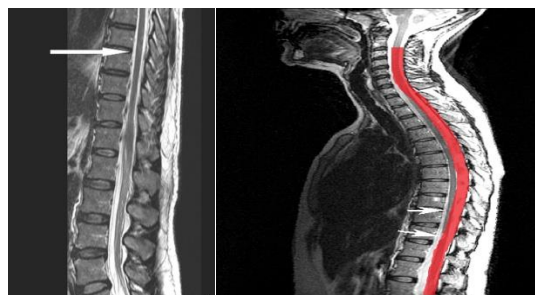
Spinal Cord MRI Image Sample
